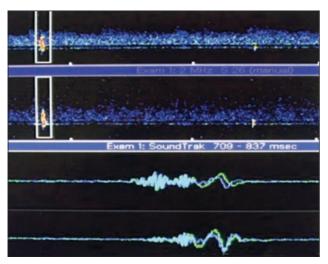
Microembolic signals (inside of the white rectangles, upper two tracings) at 56 cm and 46 cm from transcranial Doppler ultrasound probe. The lower two tracings reveal a time delay between the two signals which represent the time difference for the embolus to travel from the depth of 56 cm to 46 cm
